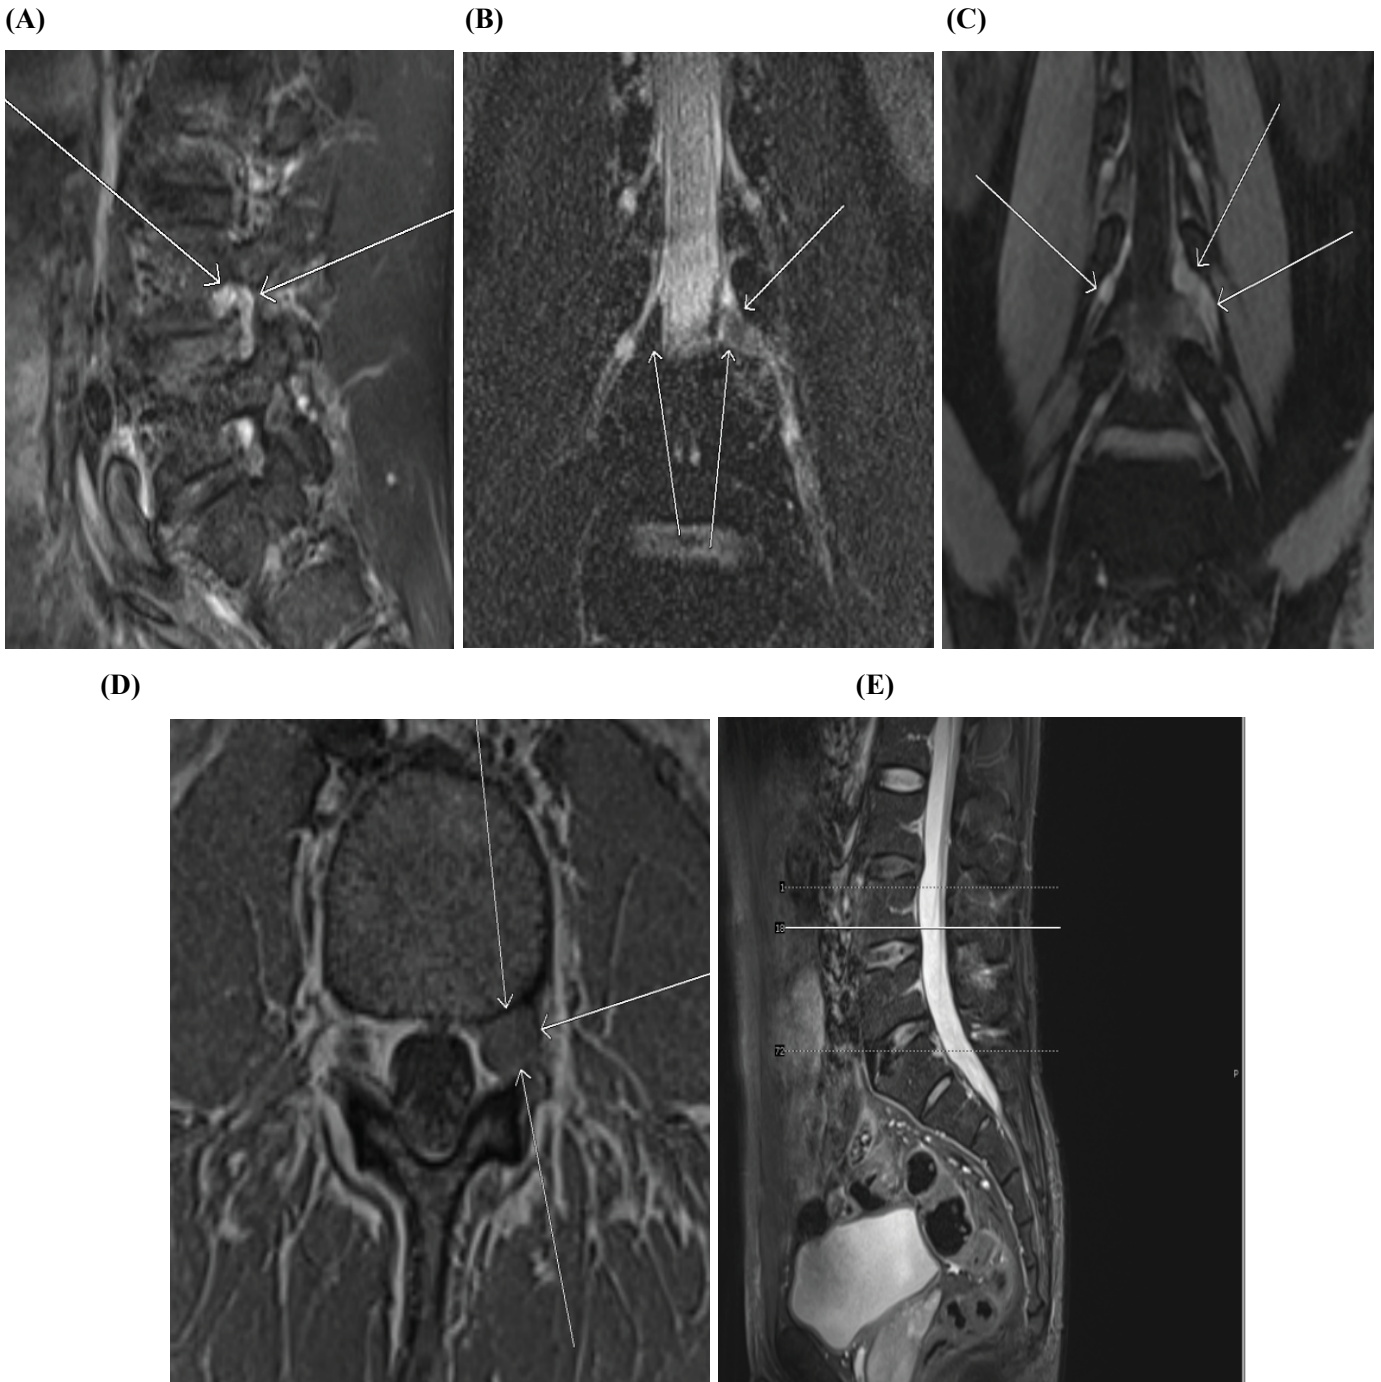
of Case 2: (A) Sagittal T2-weighted MRI with fat suppression, showing the "7" shaped high signal (indicated by arrows) behind the L4/5 disc, indicating that the extruded nucleus pulposus is moving downwards. (B) Coronal T2 weighted SPACE image. showing a regular triangular fat space on the inner side of the right L4 nerve lateral recess, while the left L4 nerve lateral recess is not clearly displayed. The inner fat space basically disappears and is occupied by the nucleus pulposus (indicated by arrows). (C) Coronal DESS image, shows that the morphology of the right L4 is normal, while the left L4 nerve is significantly thickened and swollen (indicated by arrows). (D) Axial T1-weighted MRI with fat suppression of the lower third level of the L4 vertebral body. It can be seen that the left nerve running area has massive low-signal soft tissue (indicated by arrows), and the peripheral fat space disappears. (E) Sagittal T2-weighted MRI with fat suppression.
